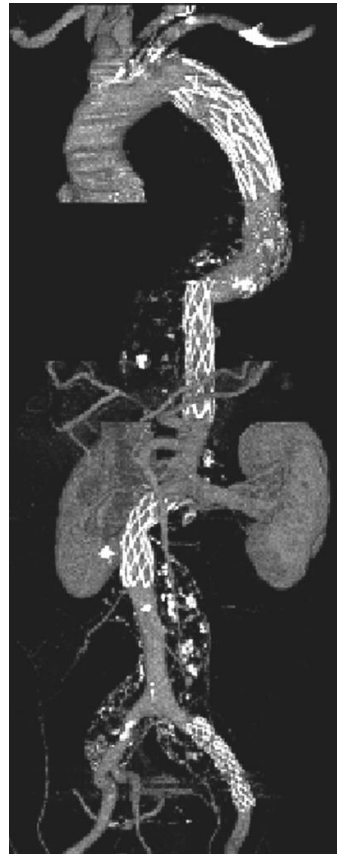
3-D volume rendering reconstruction image of CT angiography shows 4 stent-grafts deployed in thoracic, abdominal aorta and left common iliac artery. Complete exclusion of thoracic and abdominal aortic false lumen is noted. Intact blood flows of thoracic and abdominal aortic branch vessels are shown.
